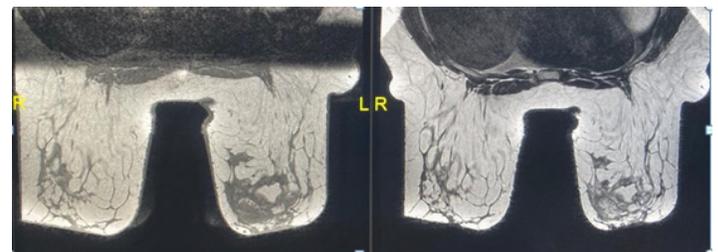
MRI-Axial T1 and T2 WI showing irregular area in the left breast inner quadrant appearing fairly bright on T1 and T2 WI, following the fat signal. Some areas low signal on T1 WI indicating blood products
